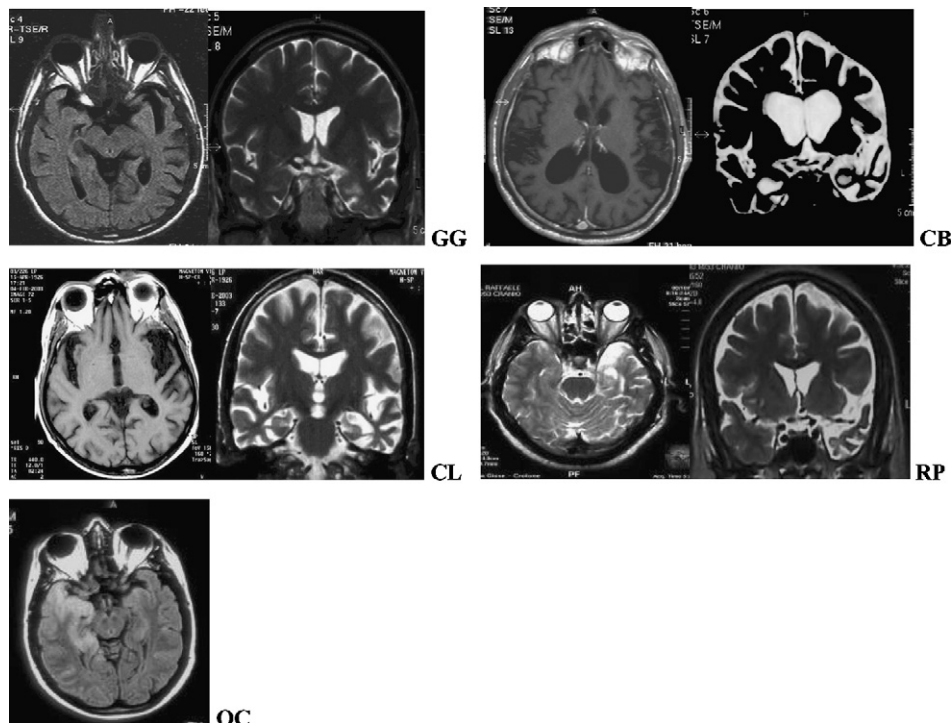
MRI scan. Semantic dementia patients (GG, CB, CL, RP): brain atrophy mainly involving the left hemisphere. Herpes simplex virus encephalitis (OC): bilateral deep temporal lesion.
